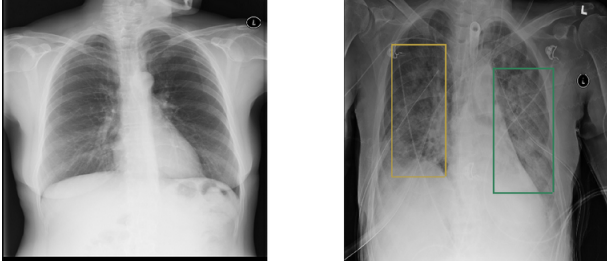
Examples of Normal class (left) and Lung Opacity class (right) chest radiograph images.
